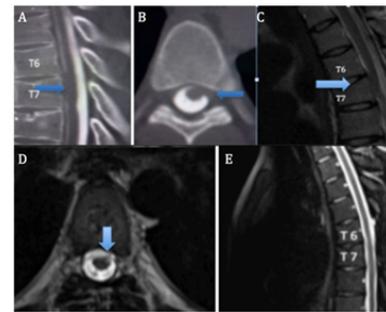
A,B) Preoperative CT myelography showing no contrast ventral to the spinal cord at T6–7. A) Sagittal image demonstrating contrast enhancement dorsal to the herniated spinal cord. B) An axial image demonstrating the ventral herniation at the level of the disc space. C) A sagittal T2-weighted image demonstrates a ventral spinal cord herniation at the level of T6-7. D,E) Postoperative MR imaging study of the thoracic spine demonstrating realignment of the spinal cord within the canal and restoration of CSF ventral to the spinal cord. .
